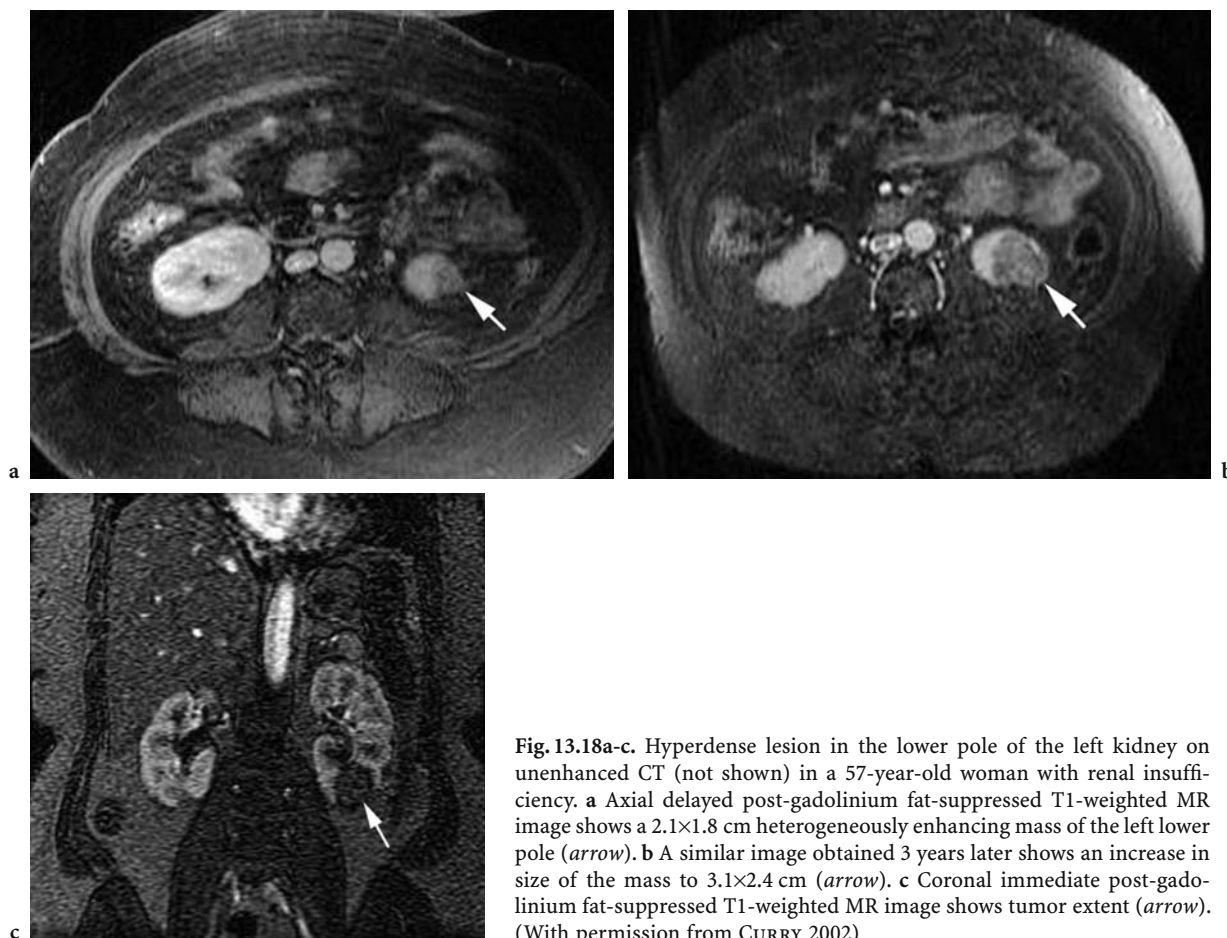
Hyperdense lesion in the lower pole of the left kidney on unenhanced CT (not shown) in a 57-year-old woman with renal insufficiency. a Axial delayed post-gadolinium fat-suppressed T1-weighted MR image shows a 2.1×1.8 cm heterogeneously enhancing mass of the left lower pole (*arrow*). b A similar image obtained 3 years later shows an increase in size of the mass to 3.1×2.4 cm (*arrow*). c Coronal immediate post-gadolinium fat-suppressed T1-weighted MR image shows tumor extent (*arrow*). (With permission from CURRY 2002)
